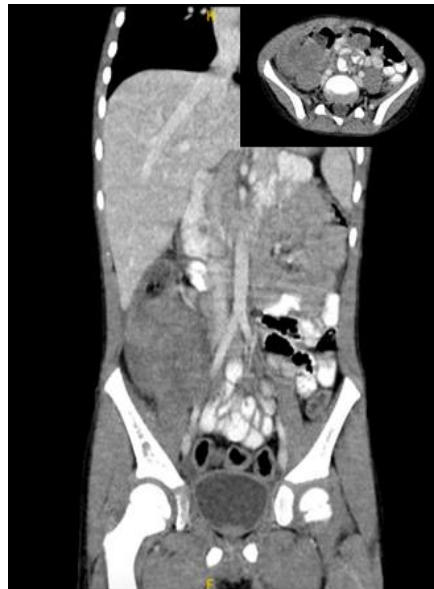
The second Abdominal CT showed worsening of the right lower quadrant heterogeneous area of soft tissue density measuring about 6.3 x 4.5 x 5 cm in transverse, AP, and CC dimensions, respectively.
